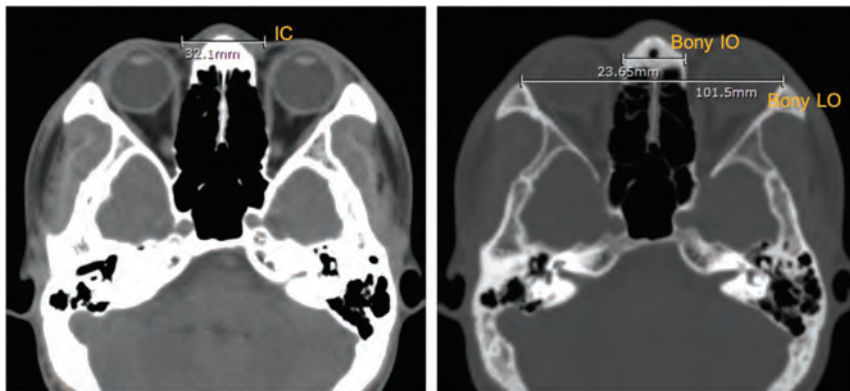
An axial CT of the brain. Left, soft-tissue intercanthal (IC); right, bony interorbital (IO) and bony lateral orbital (LO) distances, which measure 32.10, 23.65, and 101.50 mm, respectively.
